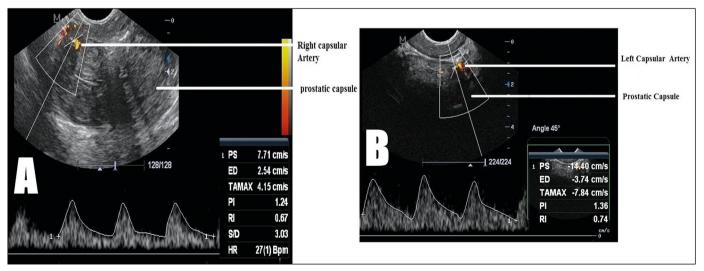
Triplex Doppler ultrasonogram of the prostate gland in the mid-transverse plane showing the urethral capsular artery.*
